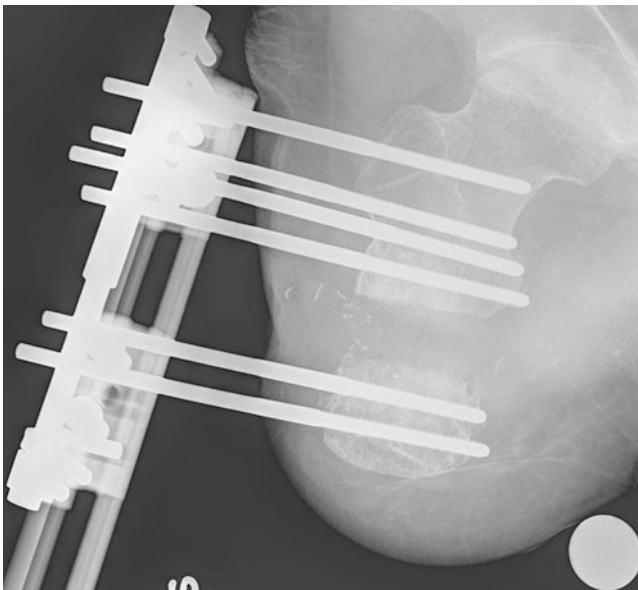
AP X-ray of the right femur during lengthening phase
